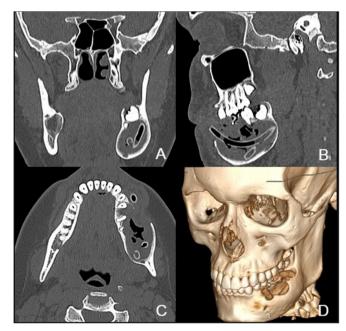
Computed tomography in the coronal (A), sagittal (B), axial (C) and 3D reconstruction (D) sections performed after the placement of the drains. It is possible to perceive the bucolingual expansion of the region of the left mandibular body, as well as the resorption of part of the vestibular cortex.
